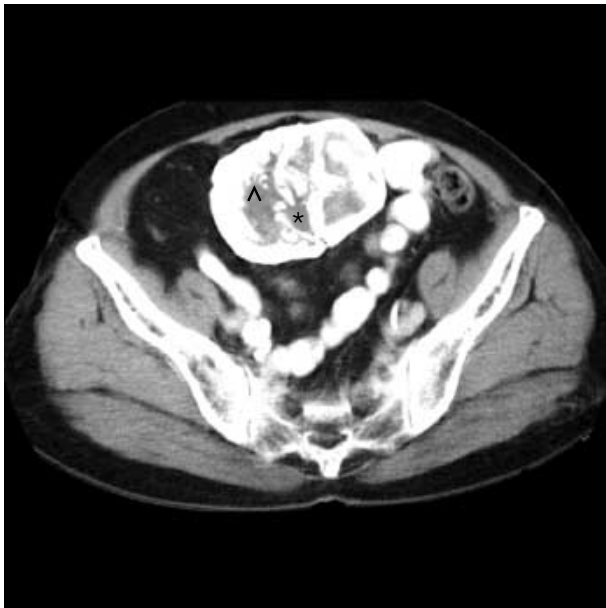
Computed tomographic scan shows a densely calcified round mass in pelvic cavity. The long bone (*) and ribs (^) are well visualized within the mass.
